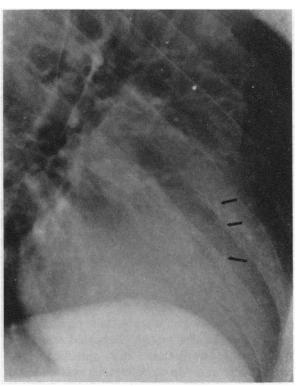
(Case 4) Plain film of chest. The catheter fragment was identified within the heart on the lateral view.
